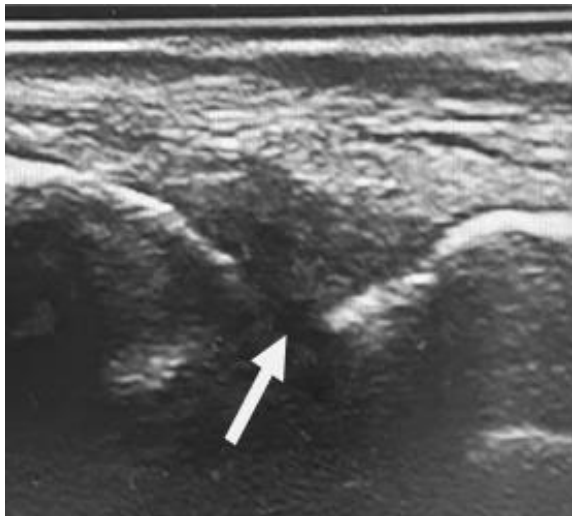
Musculoskeletal ultrasound showing grade 1 synovial hypertrophy in a metacarpophalangeal joint (arrow) in a patient with psoriatic arthritis.
